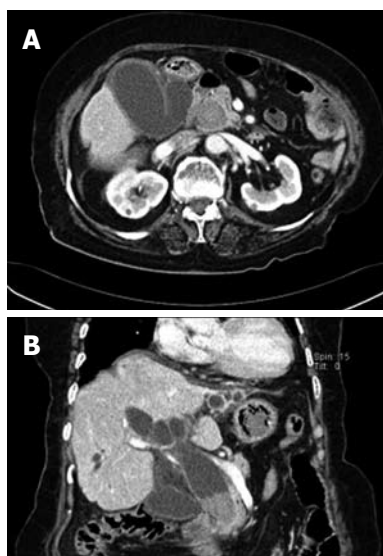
Computed tomogram revealed a huge stone in the distal common bile duct. Marked dilation of the gallbladder and bile duct was also seen. A: Axial view; B: Coronal view.
